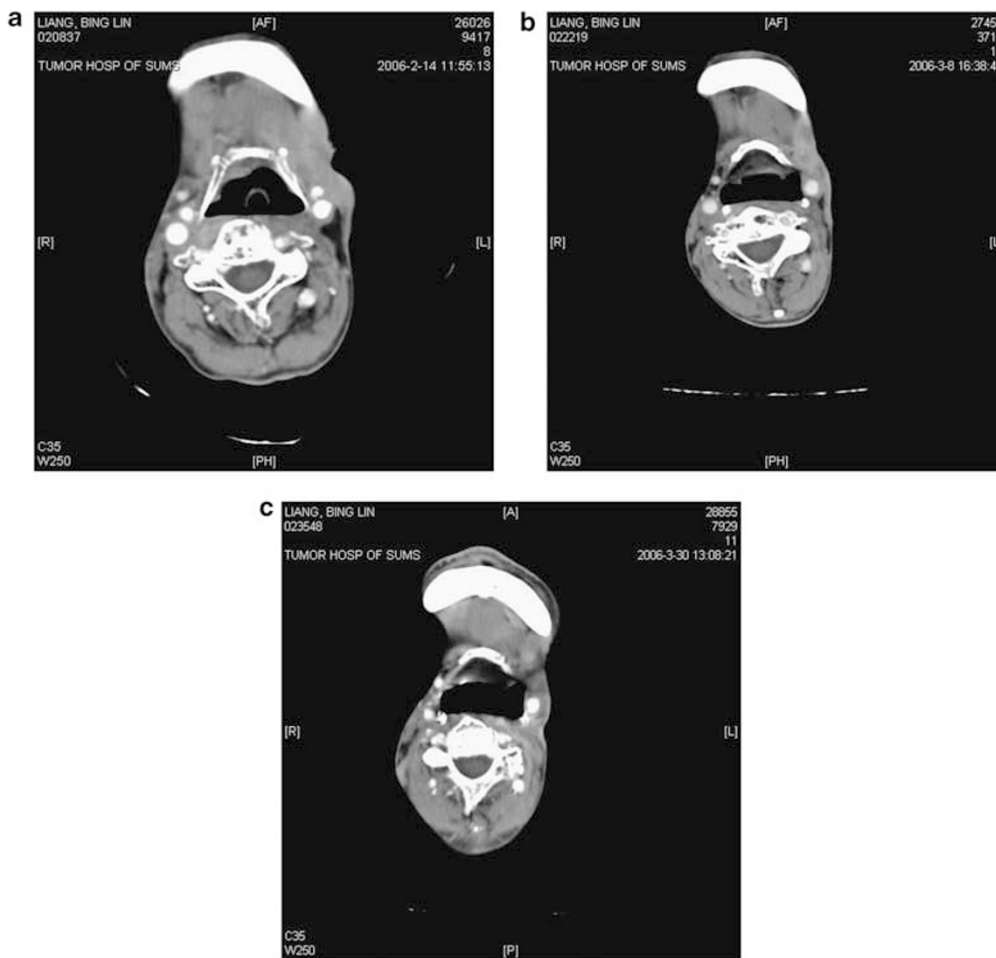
The patient was diagnosed with fibrosarcoma in the neck region and had received full-dose radiotherapy because of NPC 5 years earlier. The fibrosarcoma relapsed twice after two operations. After treatment with AdV/TK injection, a minor response (MR) was recorded in the target lesion. (a) CT scan before treatment, and further scans on (b) day 22 and (c) day 44 after injection.
